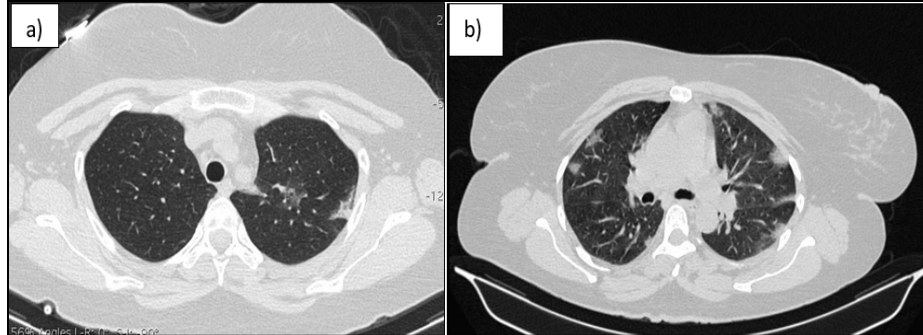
Non-Contrast Axial chest CT image A. in lung window settings of a 49-year-old COVID-19 patient showing multifocal sub- pleural ground glass opacities (GGOs) in both lungs at the time of hospital admission B. in lung window settings of a 36-year-old COVID-19 patient showing a multifocal peripheral GGO at admission
